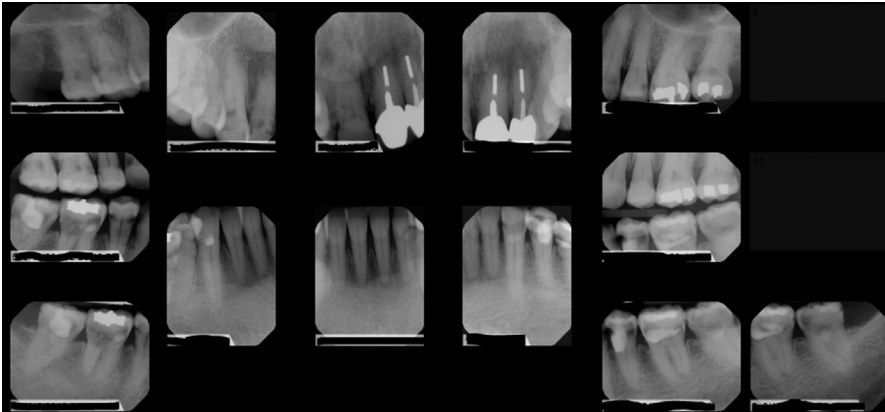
Full mouth radiographs, including bitewing radiographs made at the initial appointment, showing multiple caries lesions and root canal treatment of teeth #9 and #10.
